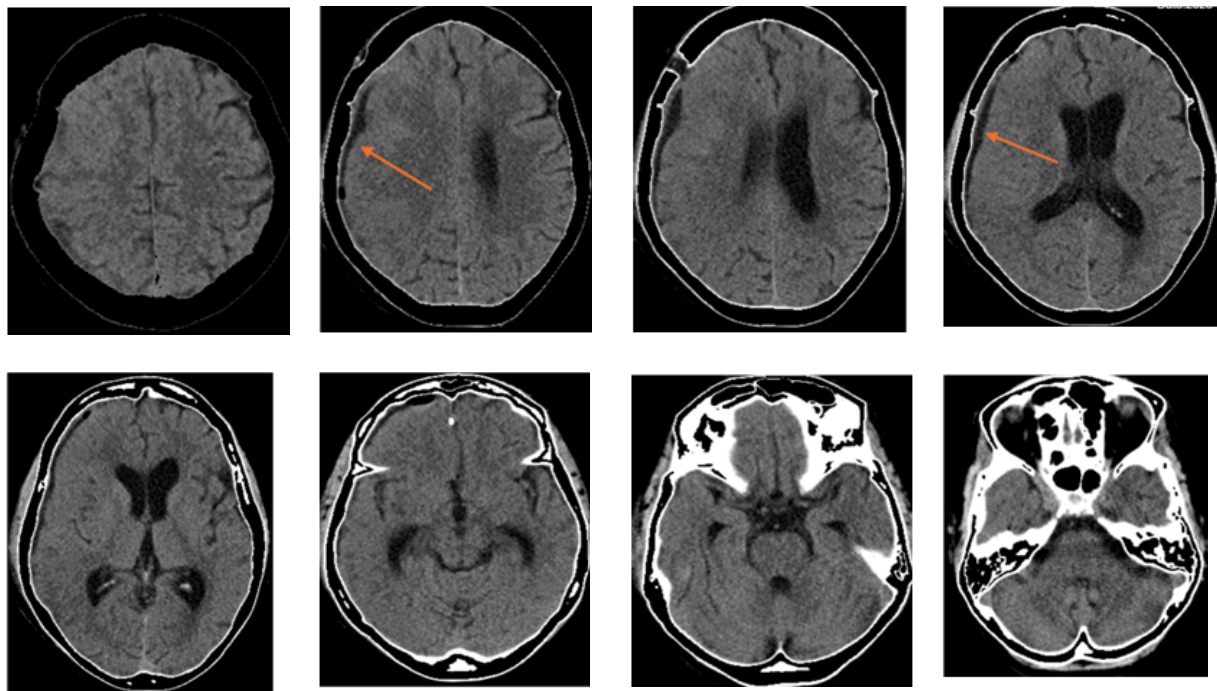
CT scan done on post-operative day 4 showing the brain is well expanded after evacuation of the subdural collection (orange arrow).
